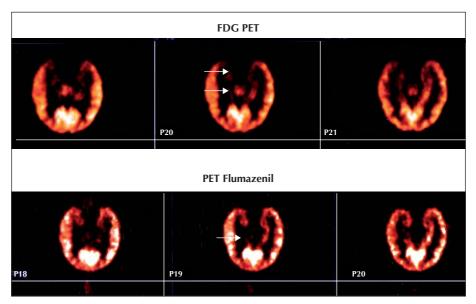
FDG and flumazenil PET.
